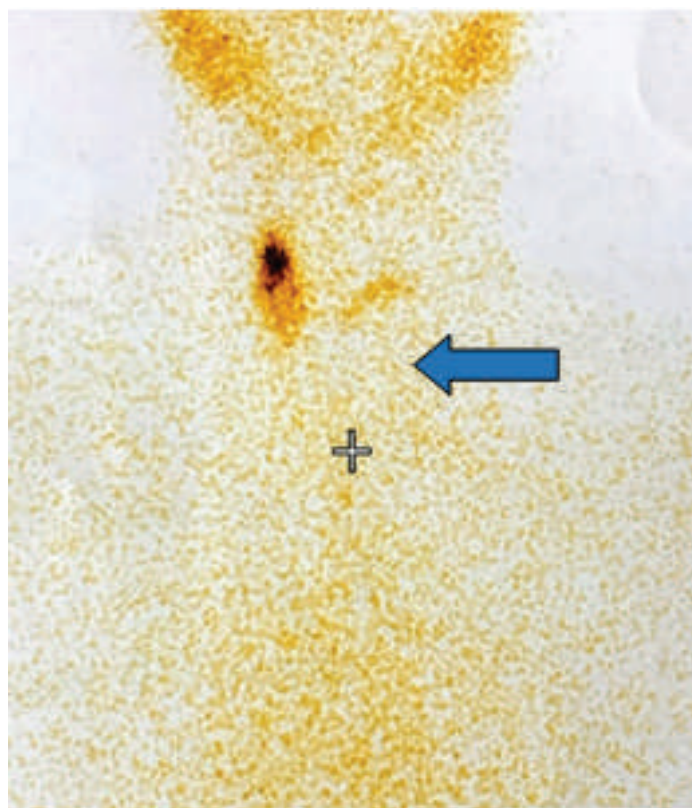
Thyroid scintigraphy showing a photopenic (cold) nodular area (blue arrow) in the left lobe region of the thyroid gland with relatively preserved tracer uptake in the right lobe
